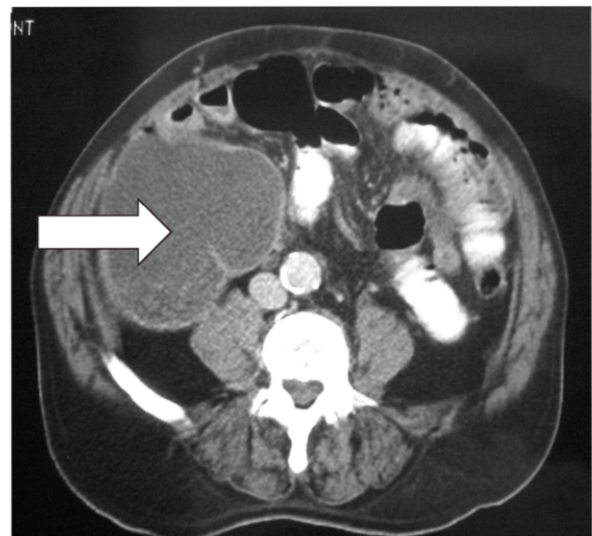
CT scan demonstrating a dilated caecum (arrow) and collapsed distal colon indicating a transverse colonic obstruction. (By kind permission of Mr E Carapeti, Mr M George, Mr A Williams, Consultant Surgeons, St. Thomas Hospital, London, UK.)
